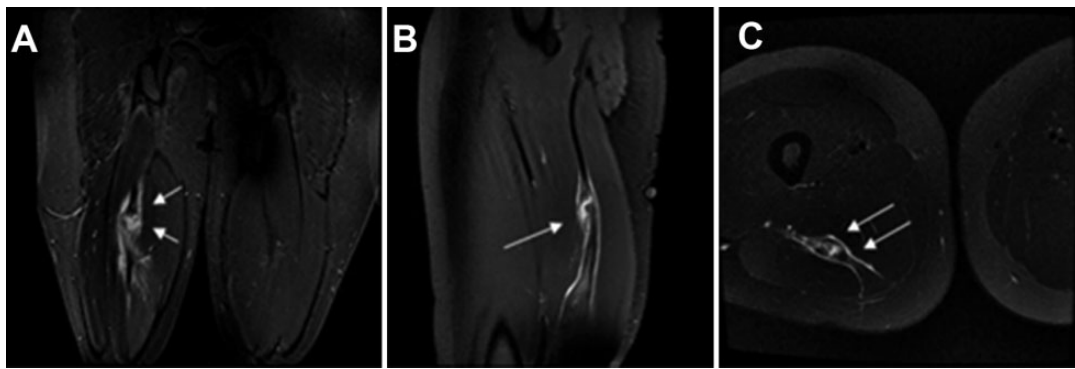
(A and B) Case 2: Initial magnetic resonance images show incomplete rupture of the central tendon of the biceps femoris (arrows). (C and D) Repeated imaging was taken 10 days later and revealed a clear gap between the retracted central tendon ends (arrows). Technique: suture with anchor reinforcement.
